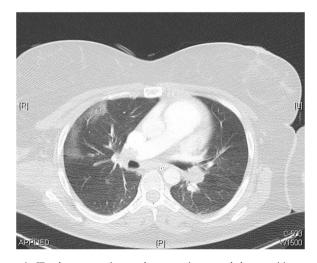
CT-pulmonary angiogram demonstrating ground glass opacities suggestive of COVID-19 pneumonitis.
